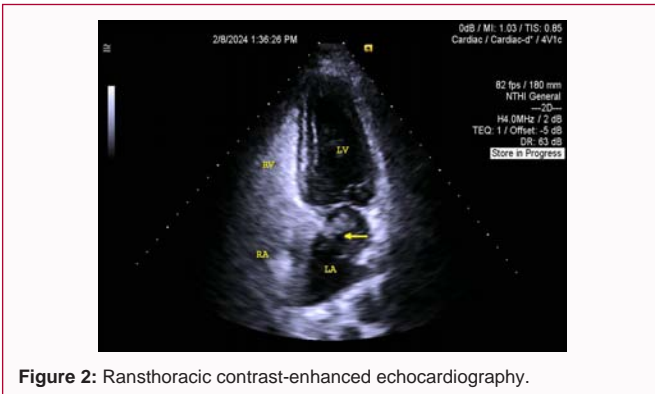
Transthoracic contrast-enhanced echocardiography.
